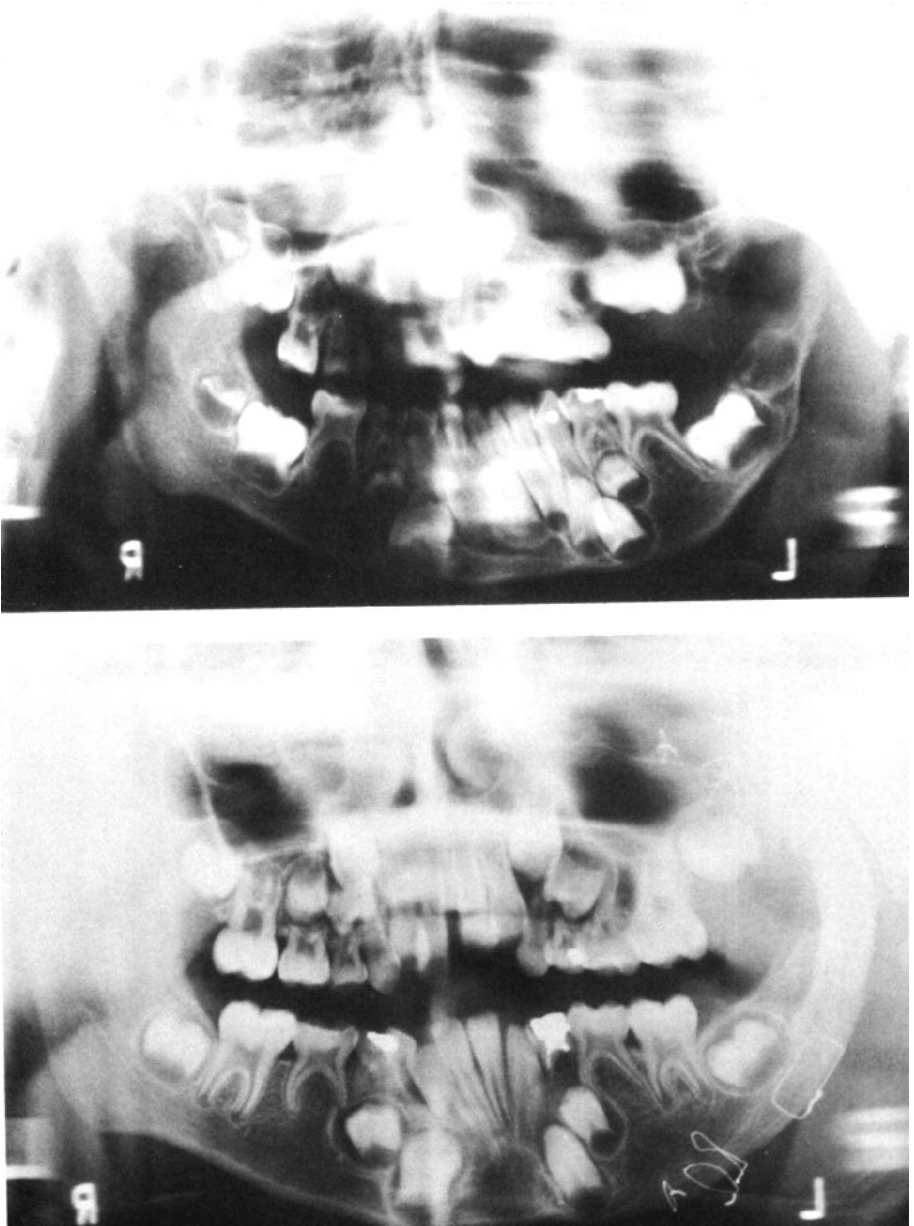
Panoramic radiographs before (top) and after (bottom) constructive surgery.
